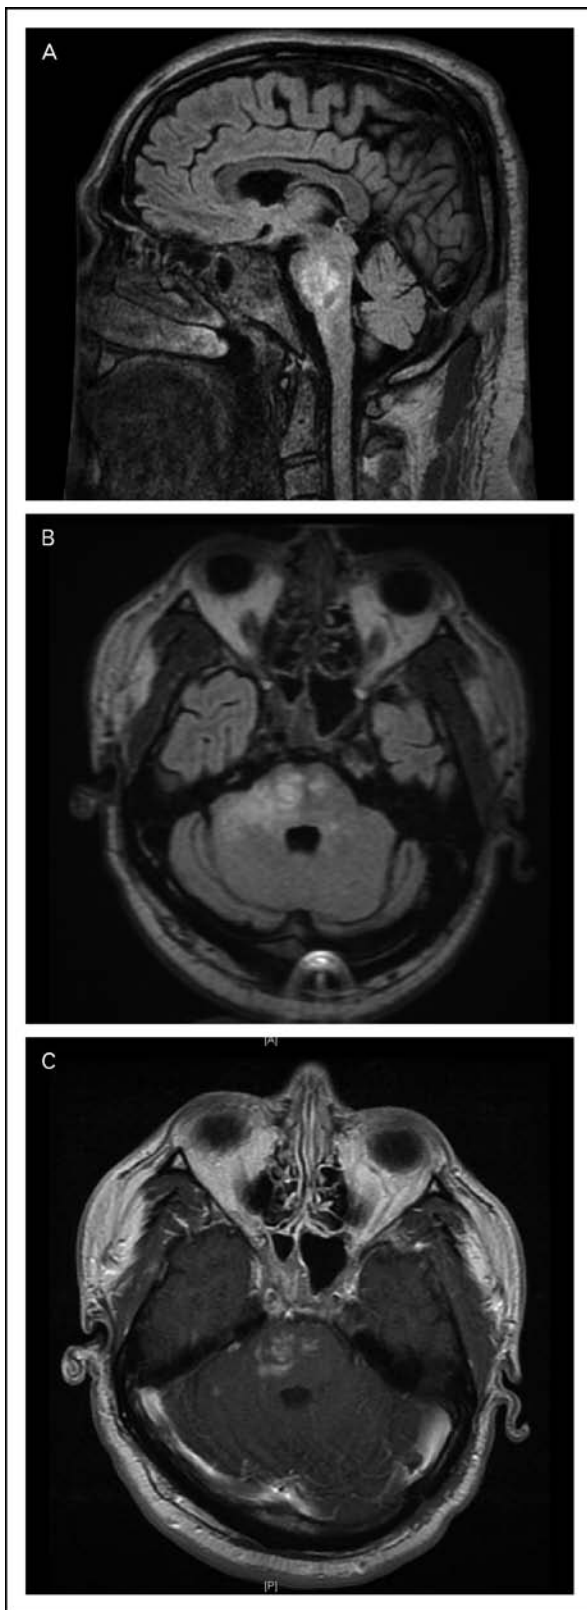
(a) Sagittal FLAIR, (b) axial FLAIR, and (c) T1-weighted images with gadolinium in a patient ultimately diagnosed with Erdheim–Chester disease. Reproduced with permission from [58]. FLAIR, fluid-attenuated inversion recovery.
